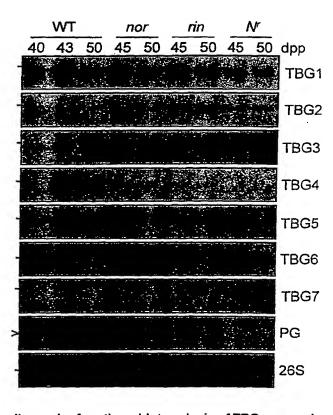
Autoradiograph of northern blot analysis of TBG expression in normal and mutant fruit tissues. Twenty μg of total RNA extracted from peel and outer pericarp tissue at various days post-pollination (dpp) was loaded in each lane. RNAs were separated in an agarose gel and transferred to nylon membrane. Blots were hybridized using the probes indicated to the right, washed to a final stringency of 0.1X SSC at 65°C and were used to expose x-ray film. A 26S ribosomal gene clone from soybean was used as a loading control for each blot and one example is shown. A cDNA clone for tomato polygalacturonase (PG) was also used as a probe to show a well characterized, fruit-ripening-specific control. The - and > marks on the left indicate the position of the tomato 27S and 18S rRNAs respectively.
